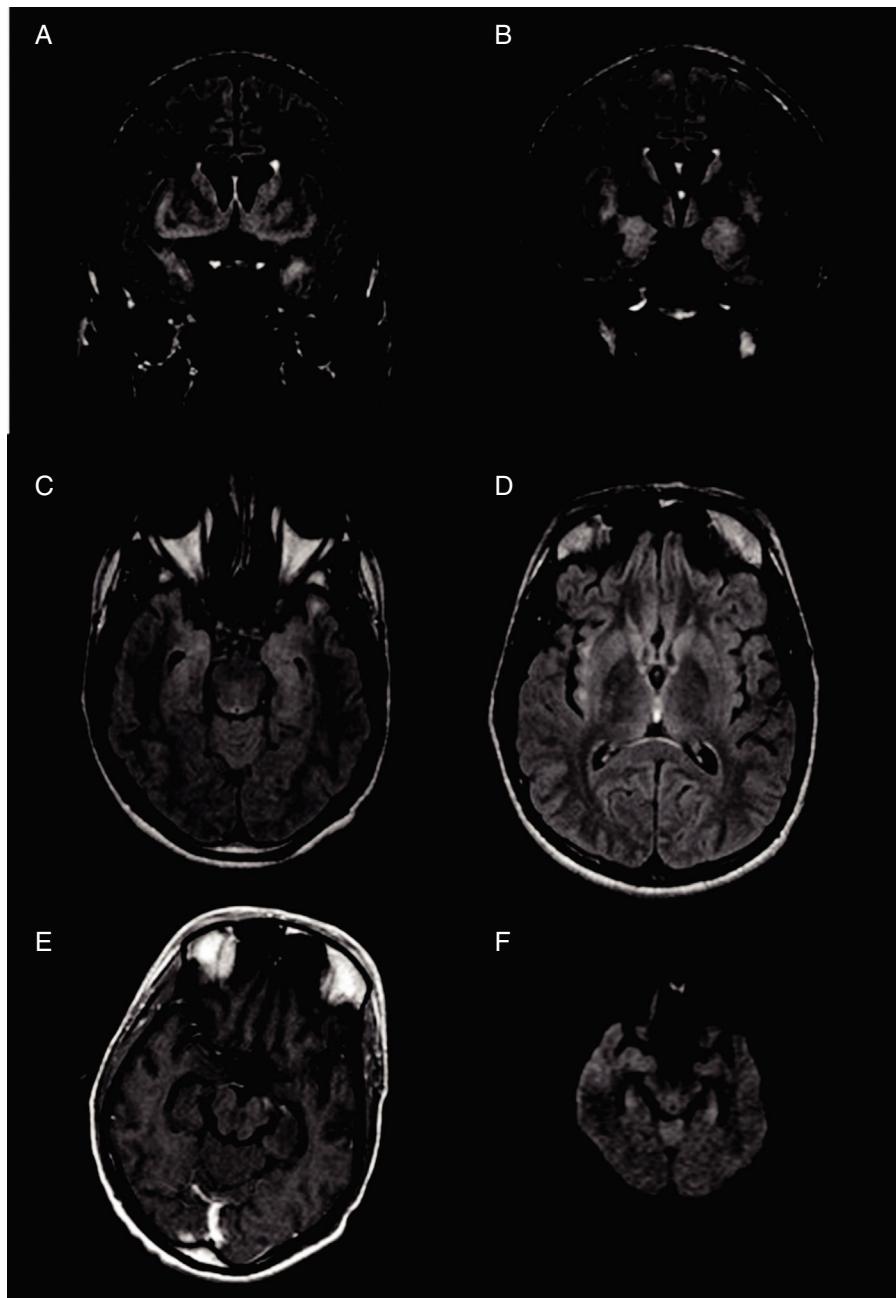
Brain MRI showing cortical hyperintensity on coronal T2-weighted FLAIR (A and B) and axial T2-weighted sequences (C and D), affecting the bilateral hippocampi, amygdalae, temporal lobes, basal and parasagittal regions of the frontal lobes, insulae, globus pallidi, and caudate nuclei. No pathological enhancement was observed after intravenous administration of contrast (E). Lesions do not cause a mass effect or show diffusion restriction on DWI sequences (F).
